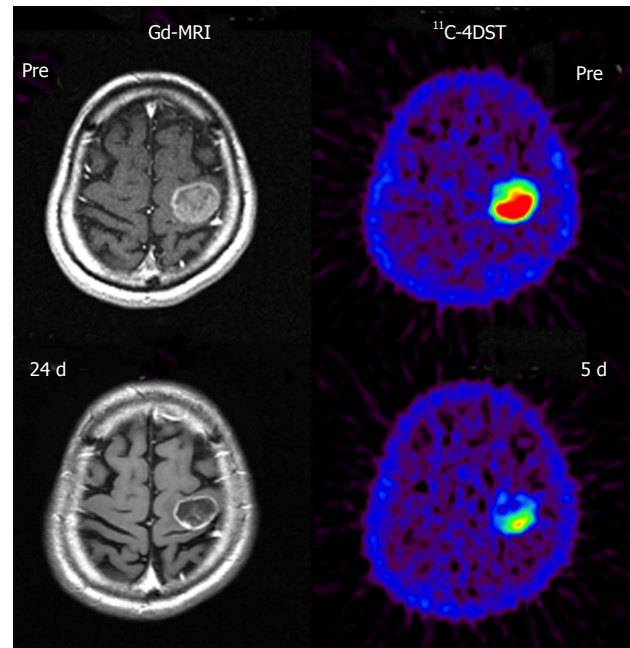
Early evaluation of the effectiveness of radiosurgery with 4'-[methyl- ^{11}C]-thiothymidine positron emission tomography. A marked decrease in ^{11}C -4DST uptake into metastatic lung cancer was observed 5 d after gamma knife radiosurgery. Although ring form enhancement with cystic formation did not disappear completely, tumor growth was halted by this treatment and the patient has maintained favorable activity of daily living 1 year after treatment. These observations indicated that the effectiveness of gamma knife therapy was correctly monitored by ^{11}C -4DST only 5 d after treatment. Reprinted from Nariai *et al.*^[14], with the permission of Springer. ^{11}C -4DST: 4'-[methyl- ^{11}C]-thiothymidine; Gd-MRI: Gadolinium-enhanced magnetic resonance image.
